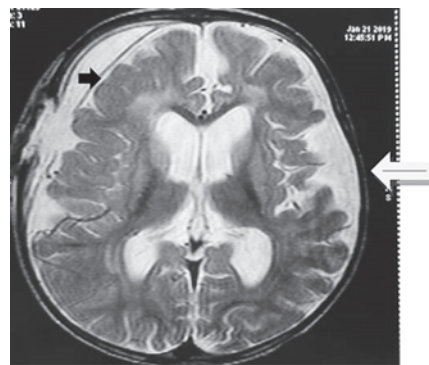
T2 weighted MRI image shows delayed myelination, abnormal signal change in bilateral basal ganglia, open sylvian fissures(white arrow) and subdural collection (black arrow).
